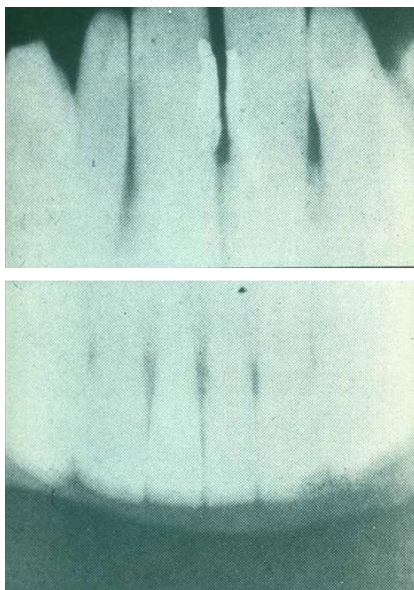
König's dental radiographs
